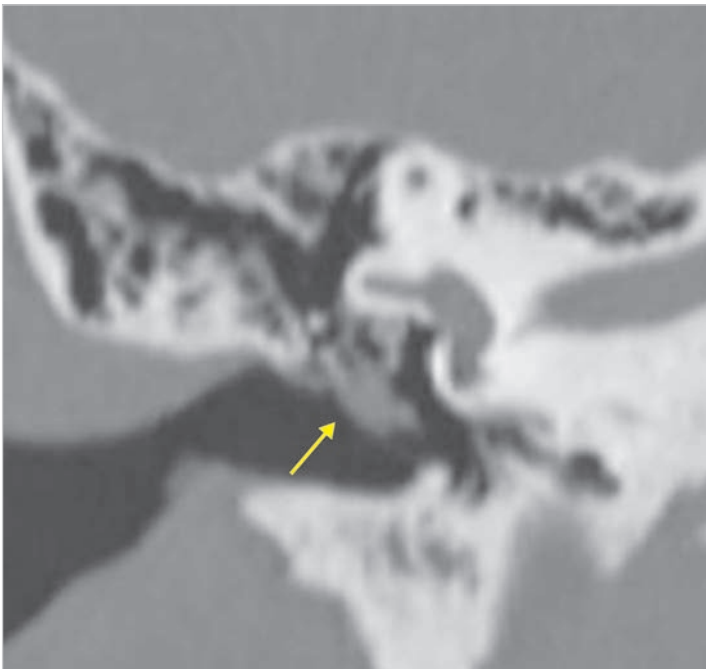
CT scan of the same case, coronal view. The cholesteatoma mass (arrow) erodes the long process of the incus. The superstructure of the stapes is missing.
